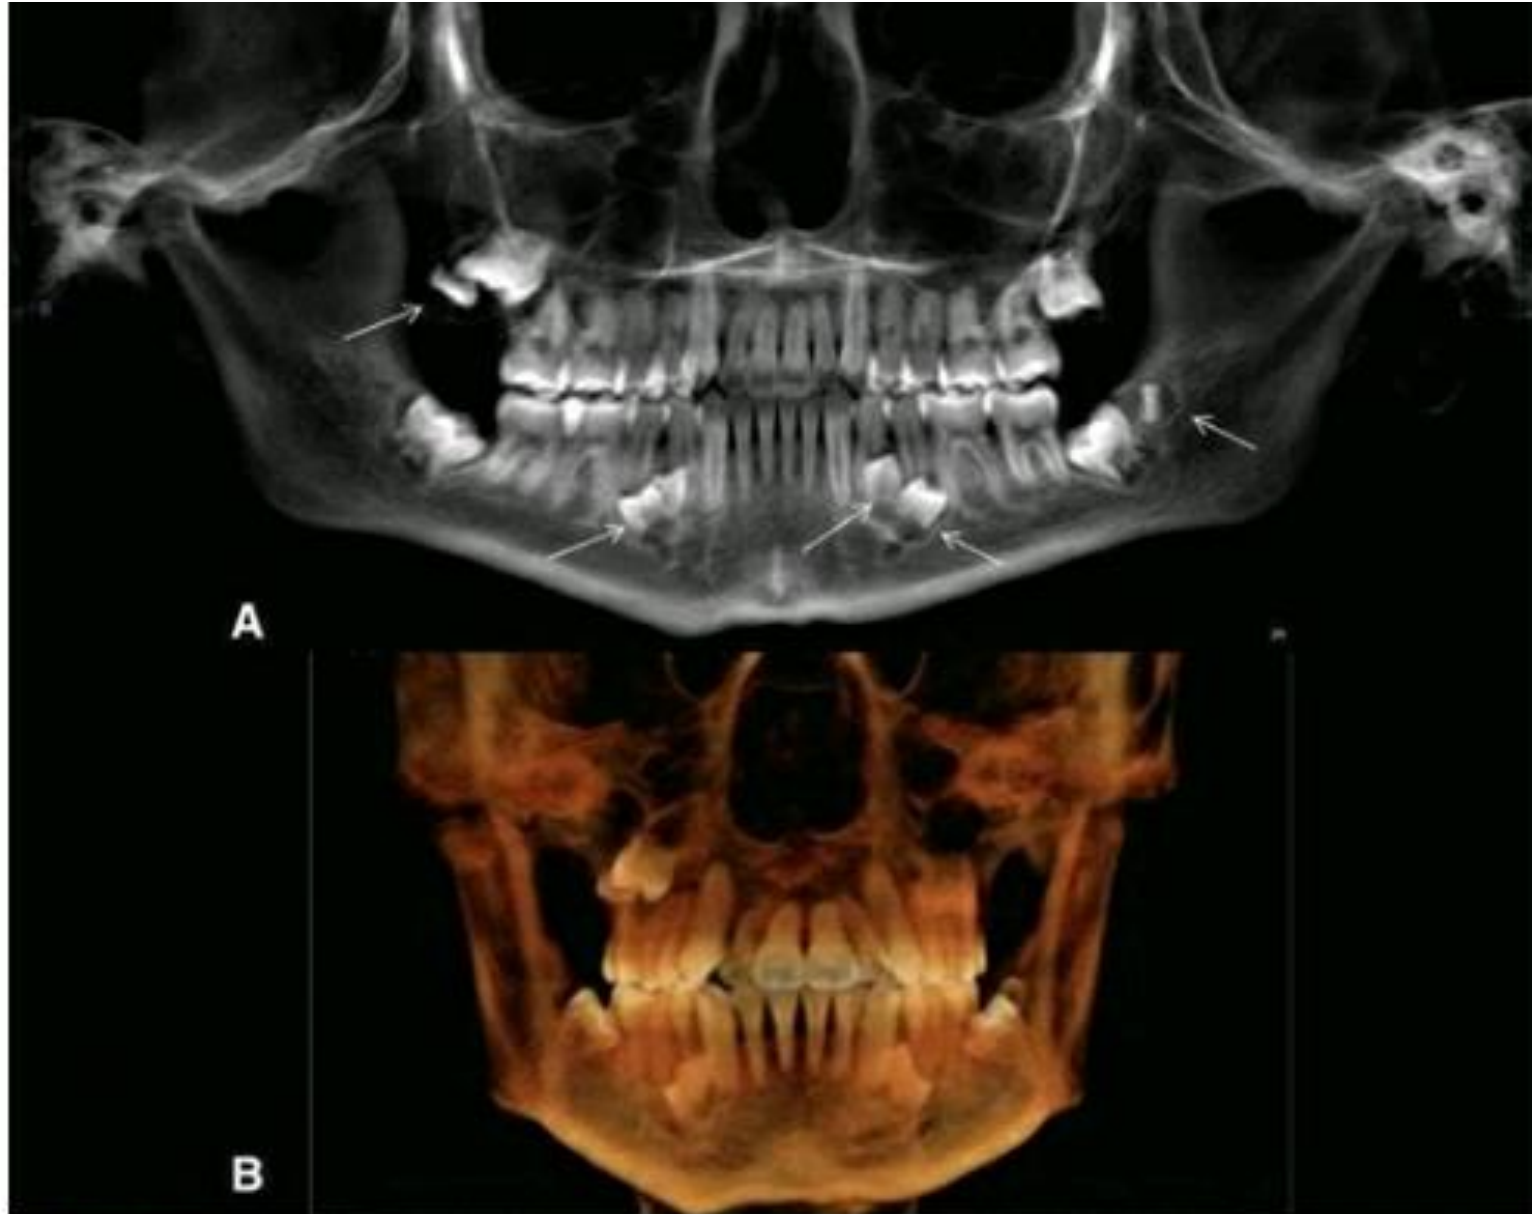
Multiple Supernumerary Teeth. (A) Panoramic reconstruction of a cone beam computed tomography (CBCT) volume (*arrows*). (B) Three-dimensional reconstruction from a CBCT volume.
